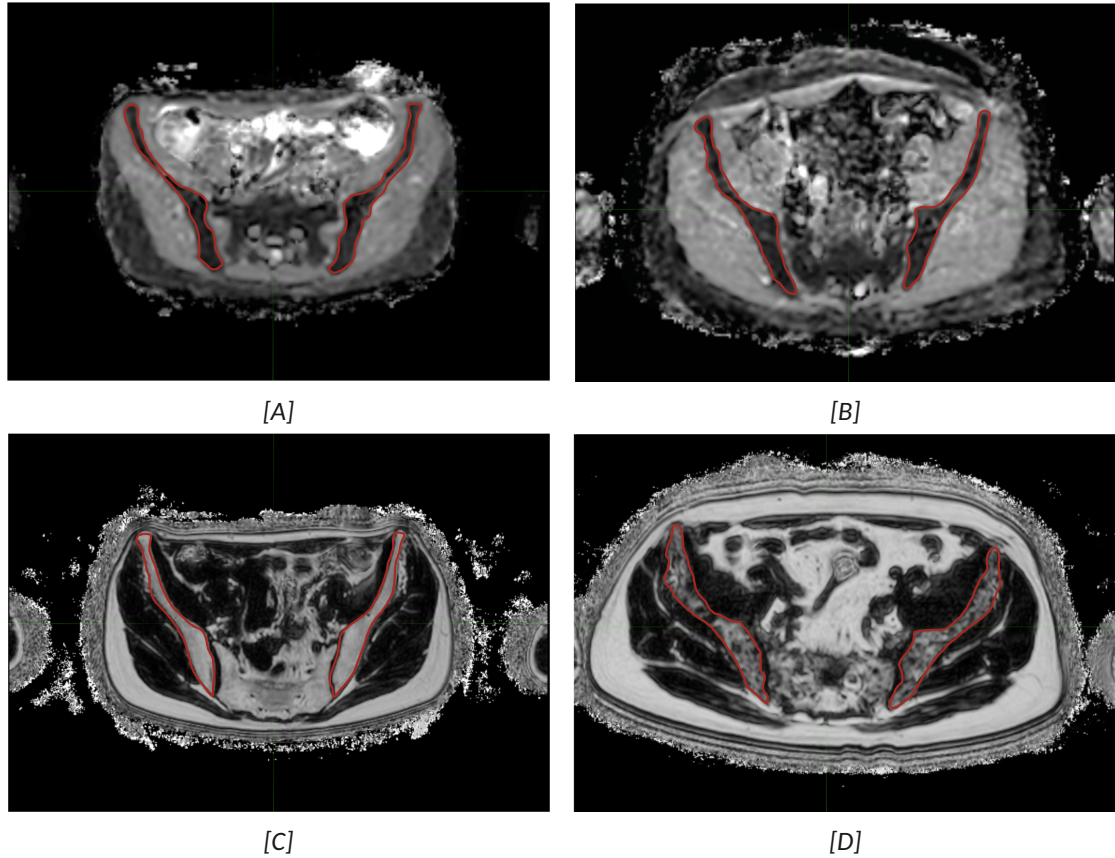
Qualitative comparison between healthy and myeloma-infiltrated pelvic bone marrow (outlined in red) in WB-MRI. ADC maps are shown in [A] for a healthy subject and in [B] for a patient with myeloma. FF maps are displayed in [C] and [D], respectively for a healthy subject and a myeloma patient.
